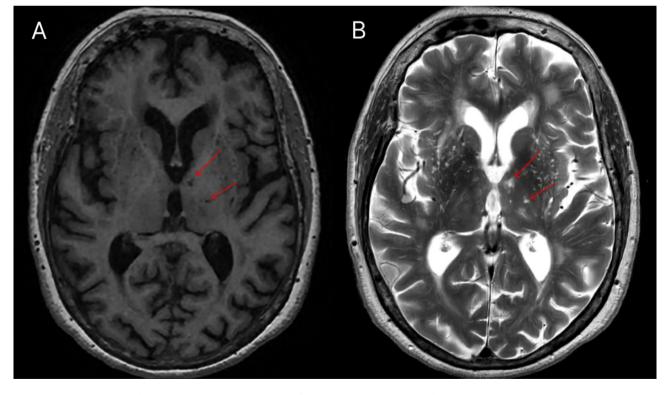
The patient's MRI conducted in October 2023, one month after the stroke. The T1 weighted imaging (A) and T2 weighted imaging (B) show the lesion in the left anterior thalamus measured up to 6 mm and in the left lateral thalamus measured up to 4 mm, with no evidence of involvement of the interthalamic adhesion. Normal representation of the corpora mammillaria without the mammillothalamic tract being affected in its course and normal hippocampal formation on both sides (not shown)
